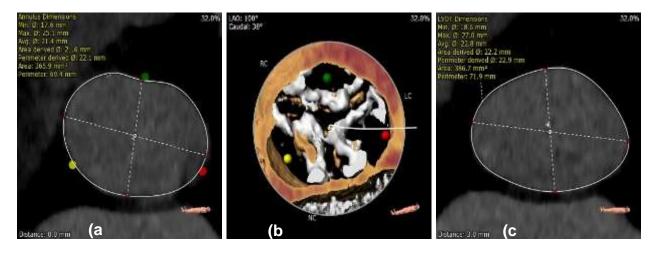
CT aortogram showing various dimensions of the aortic valve and root. Various internal diameters at the annulus (a), extent of calcification at the aortic valve (b), and LVOT diameter (c).
